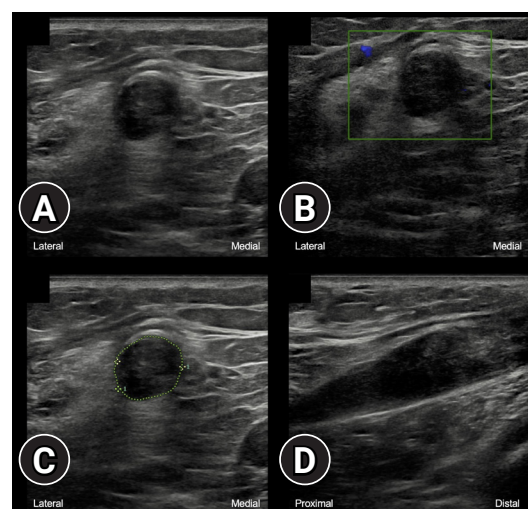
Ultrasonography of the left common fibular nerve shows intraneural swelling and loss of fascicular pattern without discontinuity after a knee posterior dislocation, in transverse axis (A) without and (B) with color doppler imaging, (C) with area (75 mm²) and diameter (9.9 mm) measurements, and (D) in longitudinal axis.
